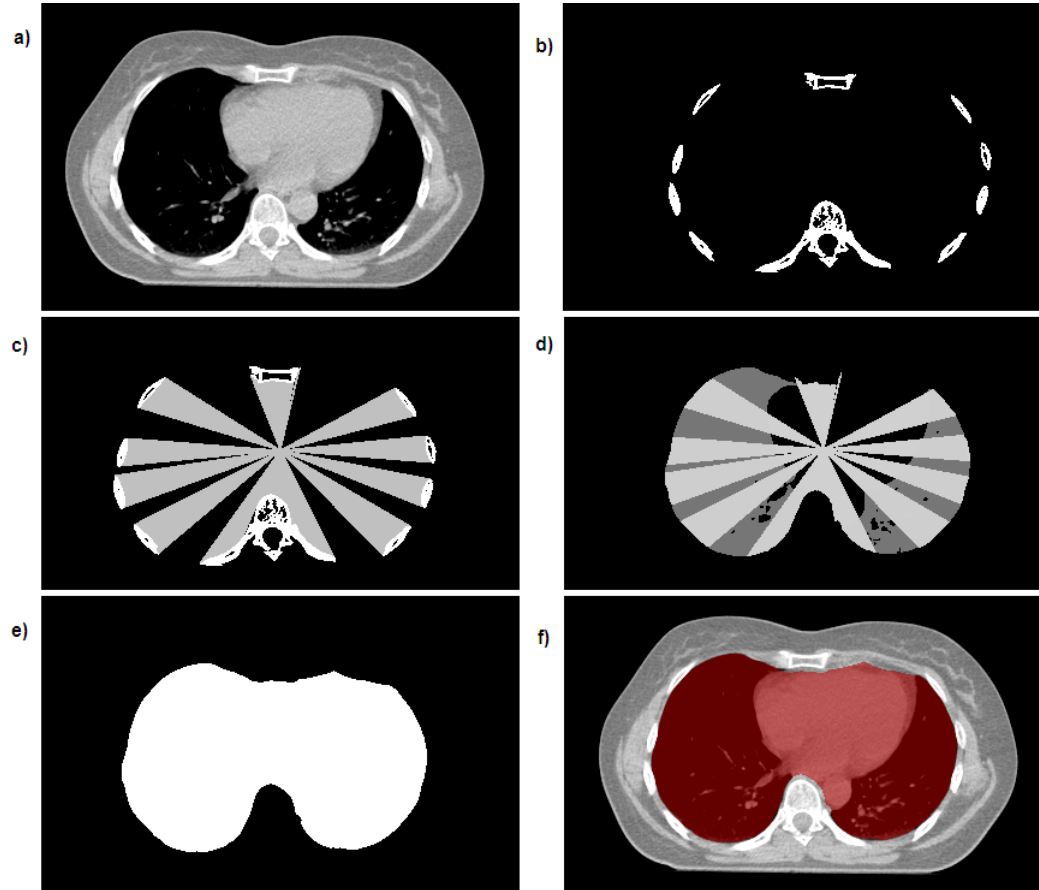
The stages of thoracic cavity segmentation using the lung region and the rib-cage as a basis for obtaining the whole volume. a) A transaxial slice through the original CT of patient 1. b) The segmented rib-cage and spine, as obtained from region growing. c) The result of tracing radial paths between the bone regions and a centre point (ribs shown in white and the radial paths in grey). d) The combined lung binary map (dark grey) and the radial paths (light grey). e) The final region obtained by dilating and eroding the volume in (d) in the transaxial and coronal slices. f) The segmented region (as in (e)) displayed in red, overlaid on the original CT slice.
